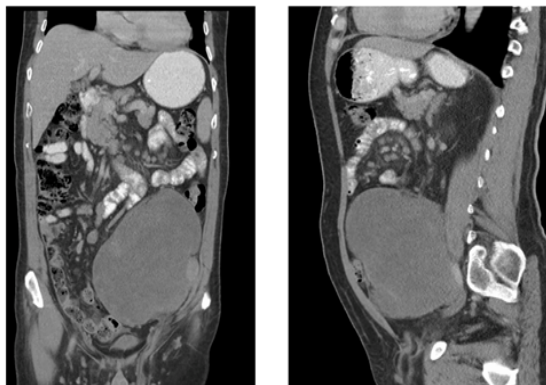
Coronal and sagittal views of preoperative CT Scan.
